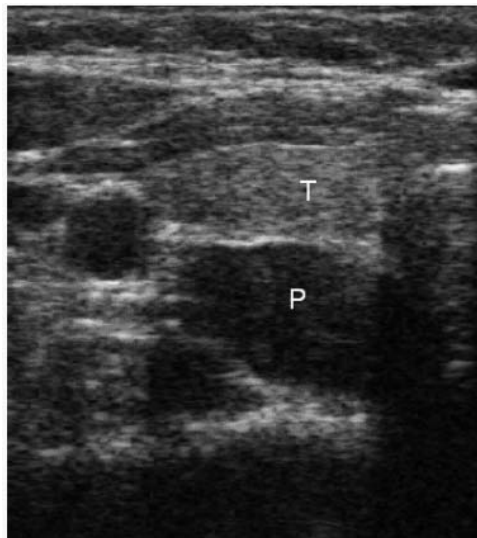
Neck ultrasound suggesting a parathyroid (P) lesion (2.9 cm) behind the left thyroid lobe (T).
